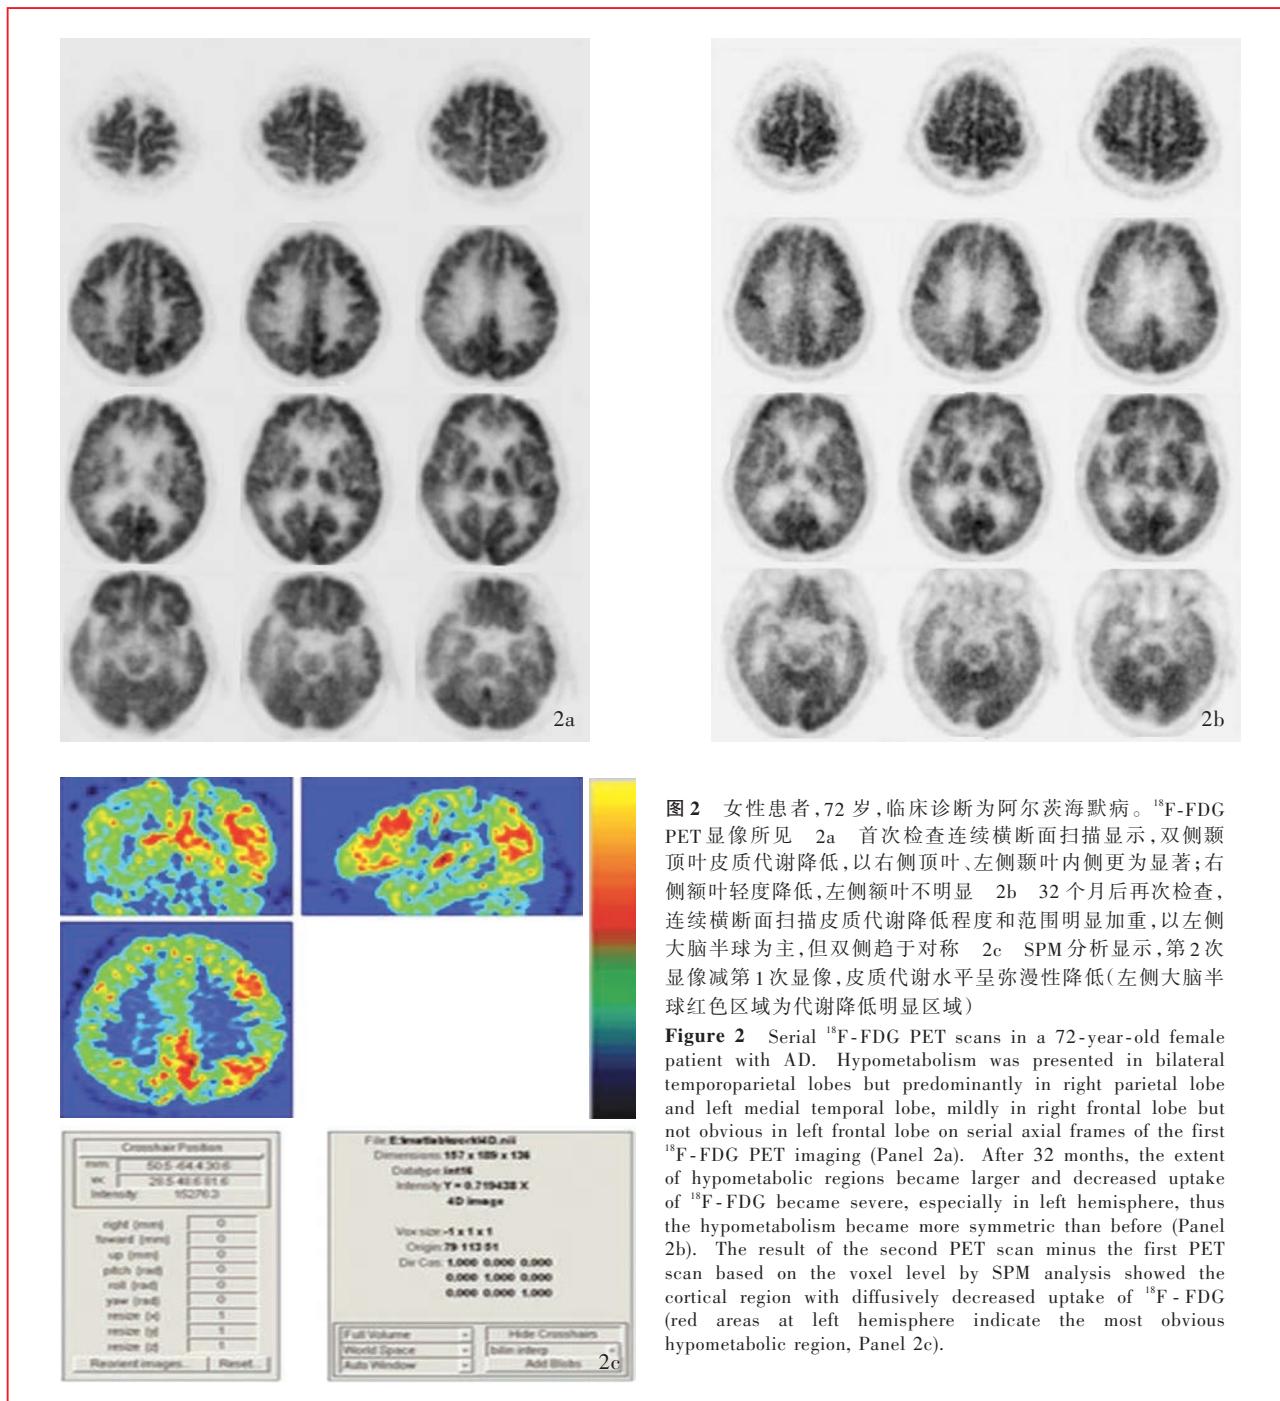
女性患者,72岁,临床诊断为阿尔茨海默病。¹⁸F-FDG PET显像所见 2a 首次检查连续横断面扫描显示,双侧颞顶叶皮质代谢降低,以右侧顶叶、左侧颞叶内侧更为显著;右侧颞叶轻度降低,左侧颞叶不明显 2b 32个月后再次检查,连续横断面扫描皮质代谢降低程度和范围明显加重,以左侧大脑半球为主,但双侧趋于对称 2c SPM分析显示,第2次显像减第1次显像,皮质代谢水平呈弥漫性降低(左侧大脑半球红色区域为代谢降低明显区域)
